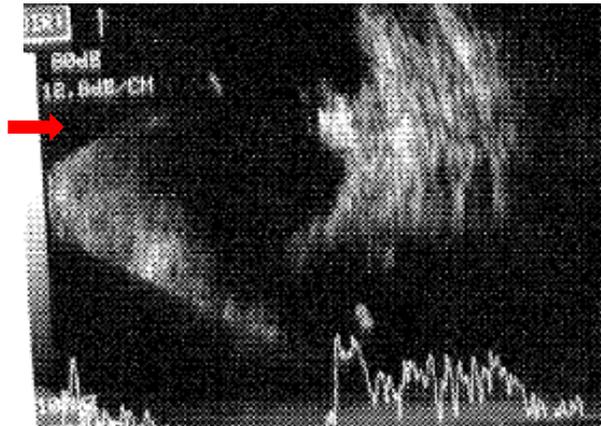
B-scan ultrasound of the patient’s choroidal melanoma showing the elevated choroidal mass with medium reflectivity.
